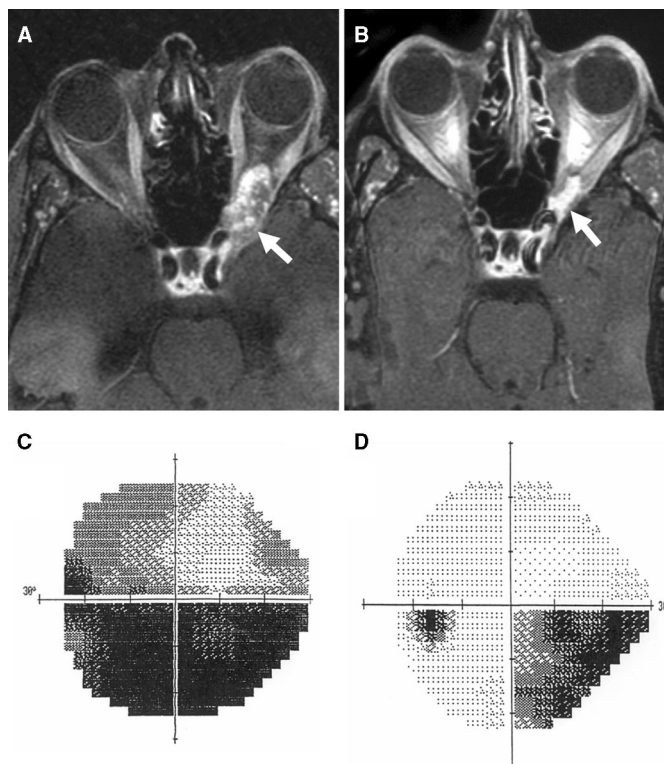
Axial T1 contrast MRI scans demonstrating residual previously biopsied meningioma in a 46-year-old man before (A) and 55 months after (B) multisession CyberKnife radiosurgery using a prescription dose of 18 Gy at 75th percentile isodose line in five sessions. Visual field examination in the affected eye immediately before (C) and 54 months after (D) radiosurgery.
